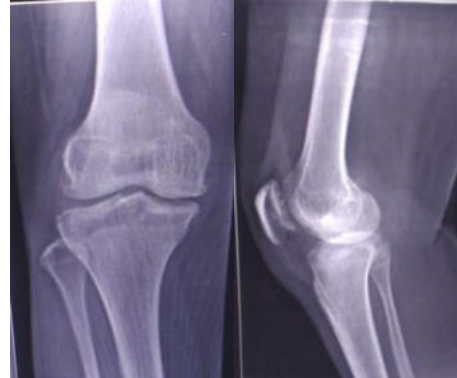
Pre op xray of patient 2
